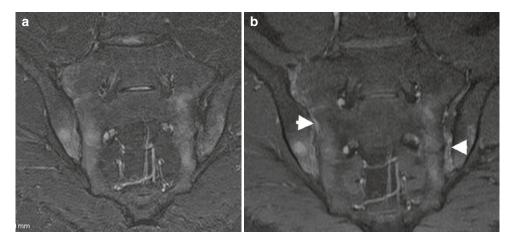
MRI of active bilateral SII. A 24-year-old male patient presenting with inflammatory low back pain. (a) Coronal STIR MRI demonstrates bilateral relatively symmetrical subchondral high signal intensity, bilateral moderate loss of joint space with early erosive changes and subtle increased signal intensity in the left sacroiliac joint of joint effusion or synovial proliferation. STIR cannot
